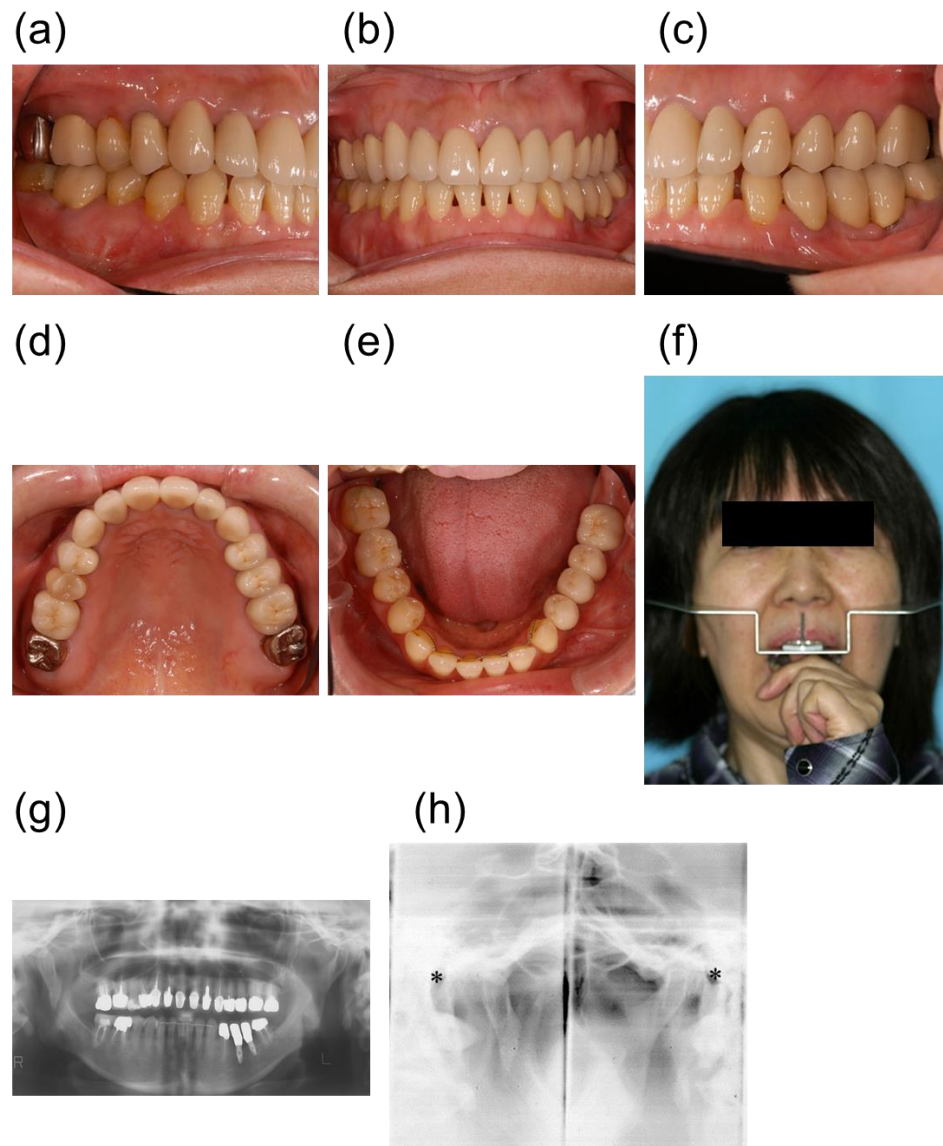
Posttreatment intra- and extra-oral photographs and radiographs. A) Right molar relationship, B) frontal view, and C) left molar relationship in centric occlusion. D) Upper and E) lower occlusal view (flipped mirror image). F) Panoramic radiograph. G) TMJ radiographs at closed mouth position. Asterisks: The external auditory foramina.
